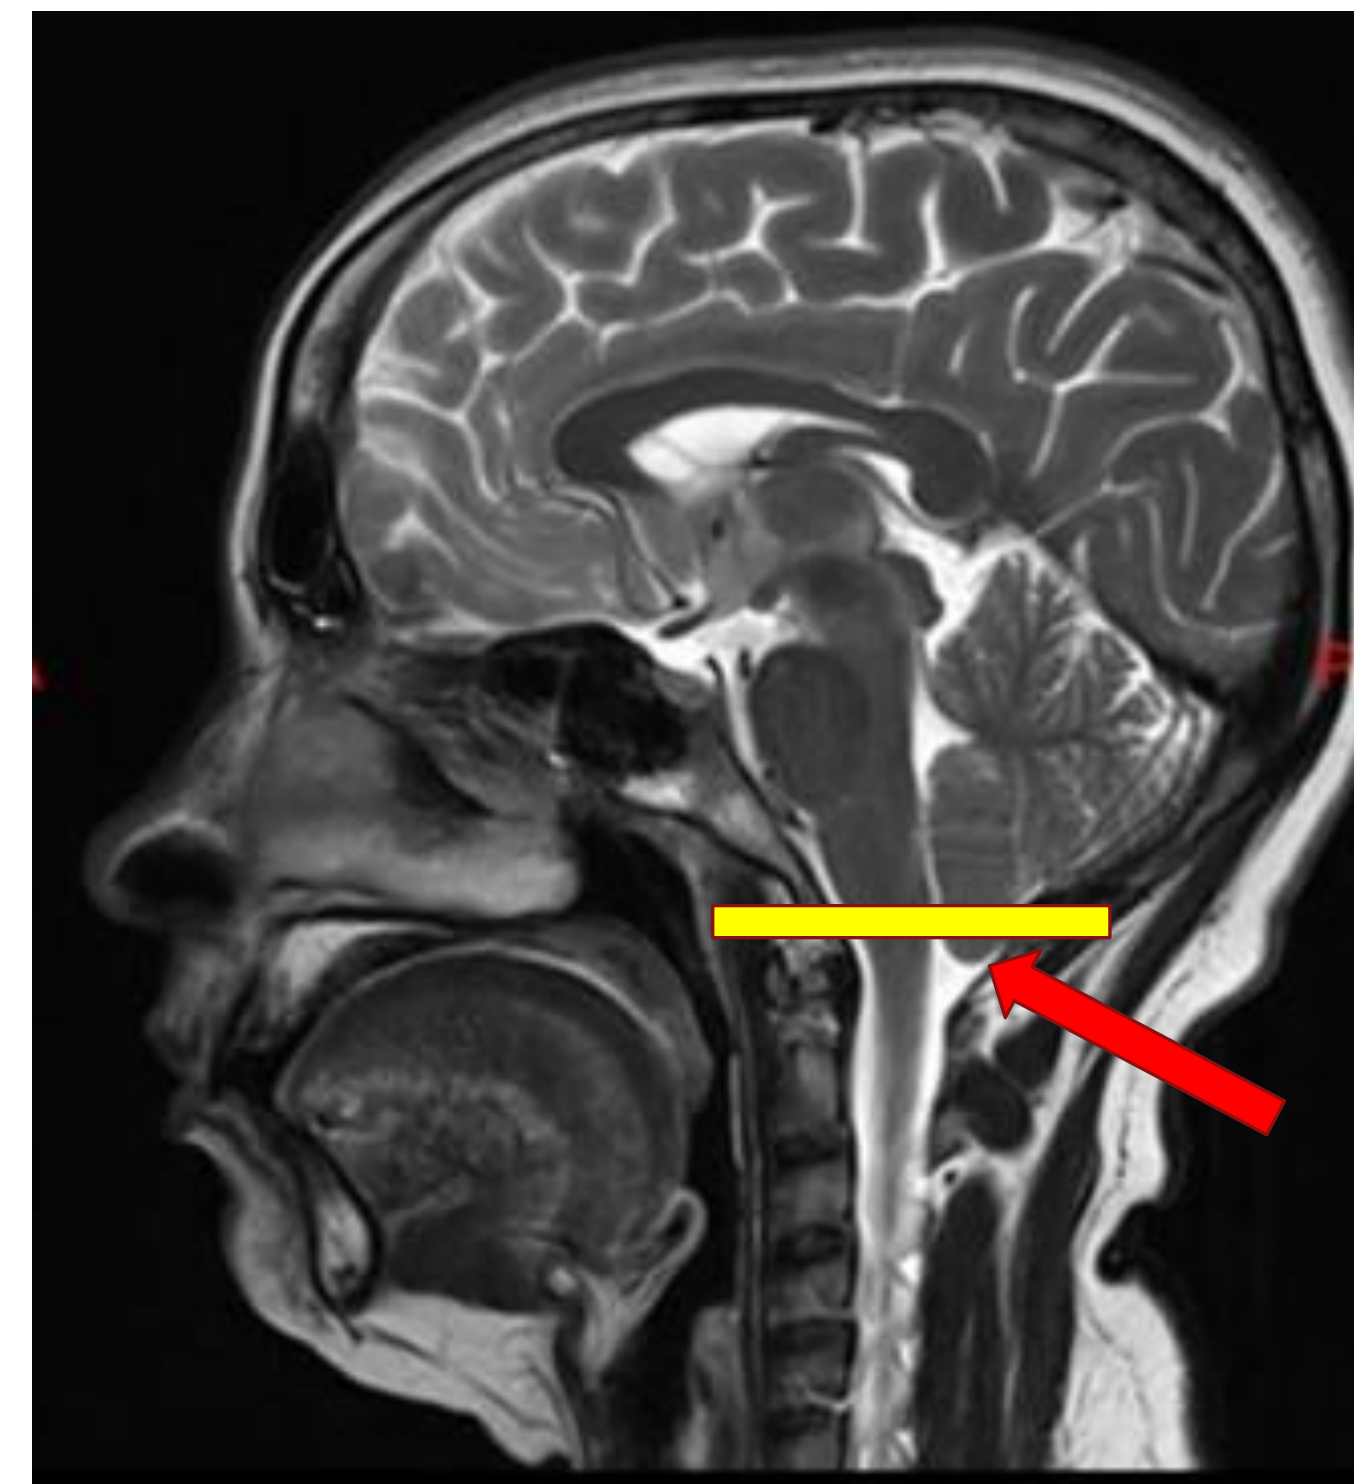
Sagittal T2 MRI showing 6 mm tonsillar descent
